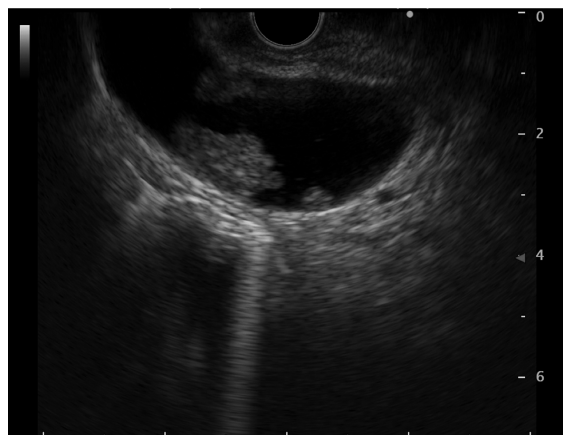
Endoscopic ultrasonography revealed multiple semi-pedunculated tumors in gallbladder. The outermost layer was preserved, and the depth of the tumors was determined to be the mucosa to the muscular layer.
